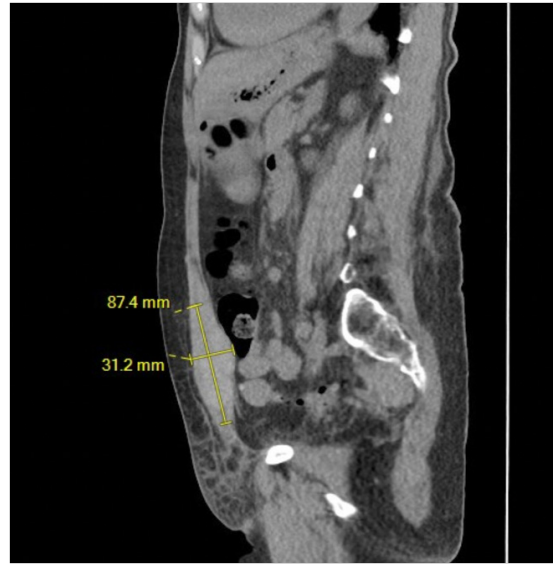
Initial patient presentation on postoperative day 7 with a CT scan showing a left-sided 4.3×3×8.7cm rectus sheath hematoma.
